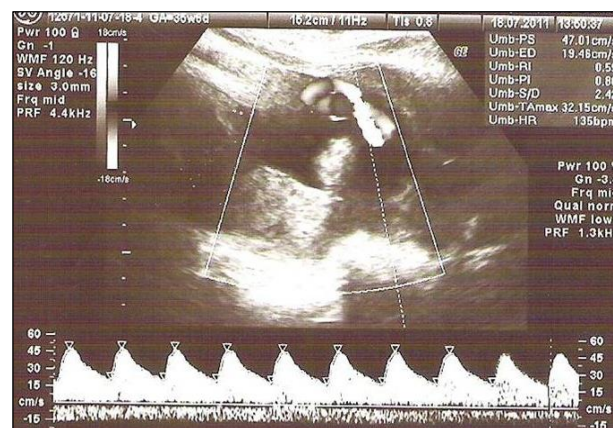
Normal colour doppler of the umbilical artery waveform at 35 wks (s/d ratio =2.42, ri =0.59 , pi = 0.86)
